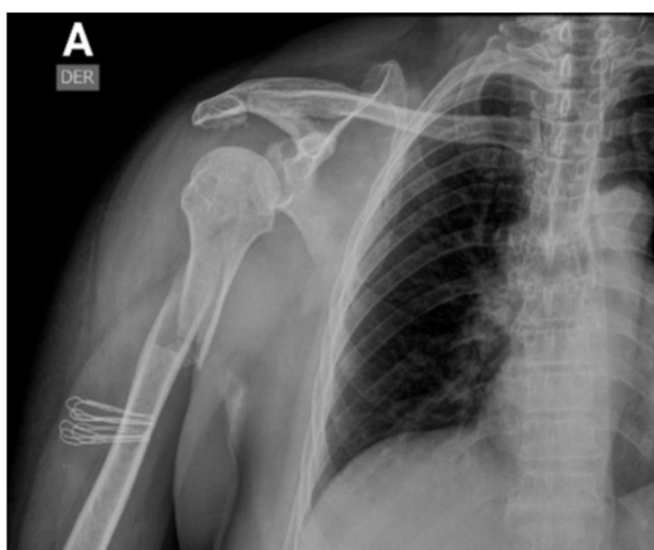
neutral anteroposterior preoperative radiograph of the right shoulder after a traumatic event with displaced diaphyseal fracture.
